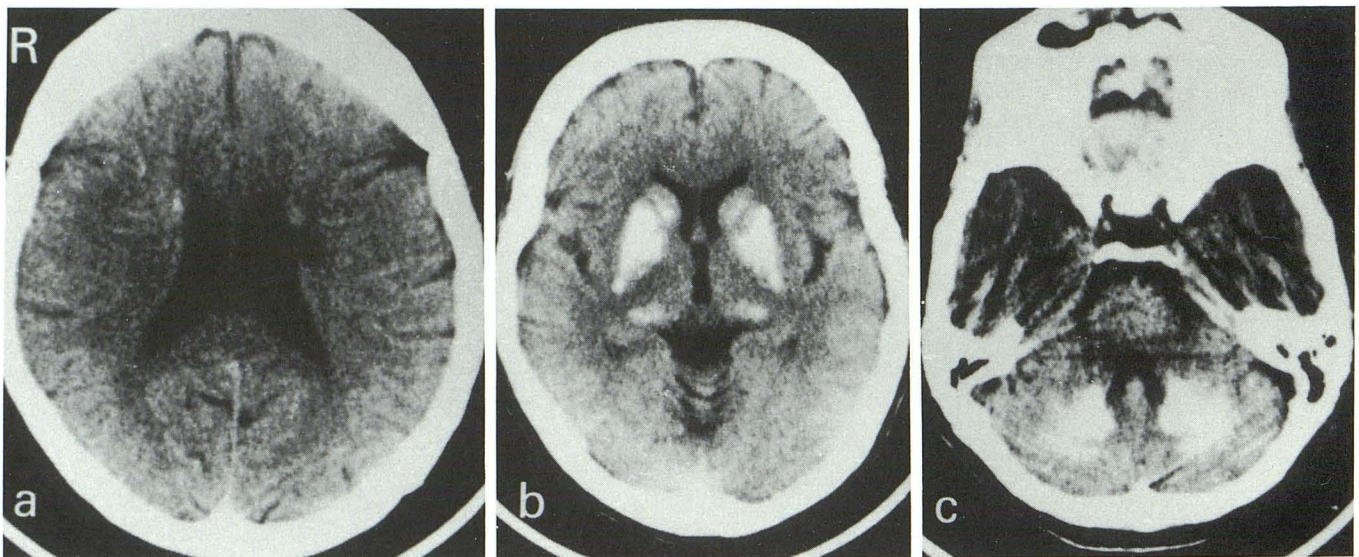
CT in June 1989 demonstrated bilateral calcifications in the lentiform nuclei, caudate nuclei, thalamus, dentate nuclei, and the white matter of the cerebellar hemispheres. Low density areas were noted in the left corona radiata and internal capsule.
